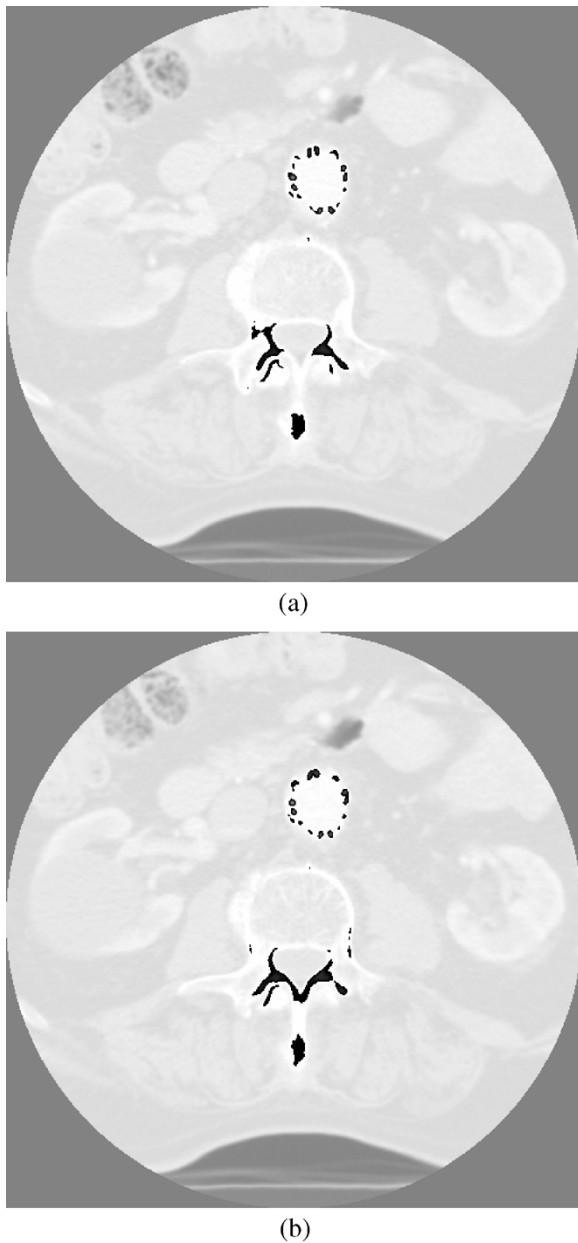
Two consecutive frames with high motion in sequence "CT." (a) The 43rd frame. (b) The 44th frame.
